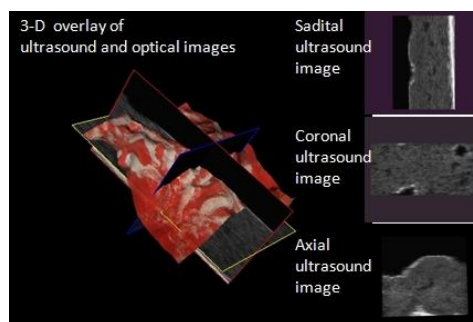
overlap display system of 3-D ultrasonic image and 3-D laparoscope image
